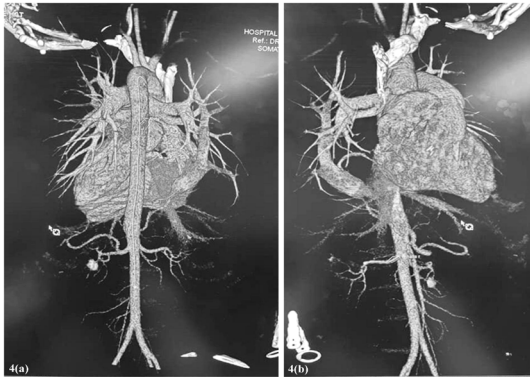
3D-reconstructive images from computed tomography angiographic scan of the pulmonary vessels confirming Scimitar syndrome
